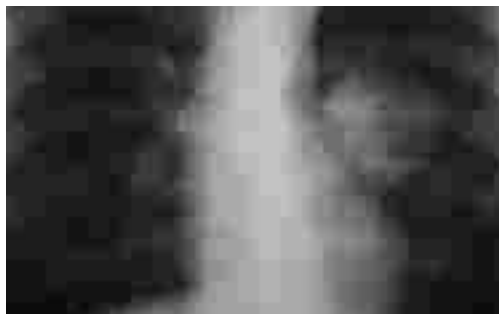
Chest radiograph of the face. Peripheral cancer of the lower left lung*
